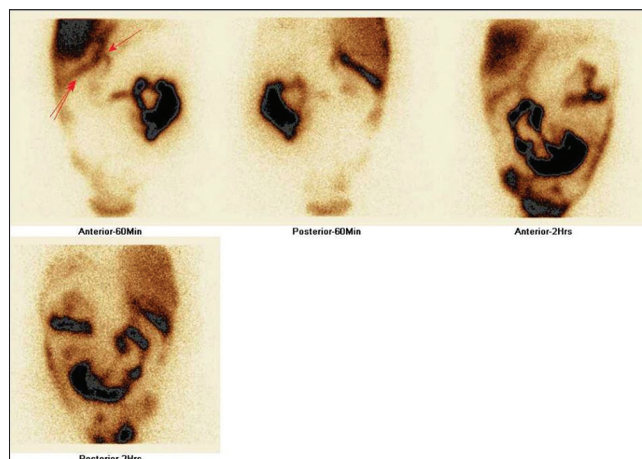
Hepatobiliary scintigraphy static 60 min and 2 h images showing site of the leak (single arrow) and then through the inferior border of the liver (two arrows)
